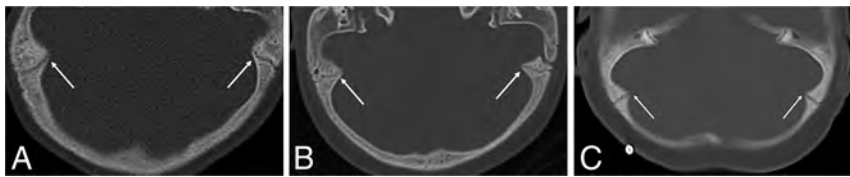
CT images show bilateral internal hypertrophy yet open occipital mastoid sutures (white arrows) in 3 different patients with MPS IH. A, This is the first patient with CT at the head bone window obtained at 1 year of age. B, This is the second patient with CT at the head bone window obtained at 1.6 years of age. C, This is the third patient with CT at the head bone window obtained at 1 year of age.
